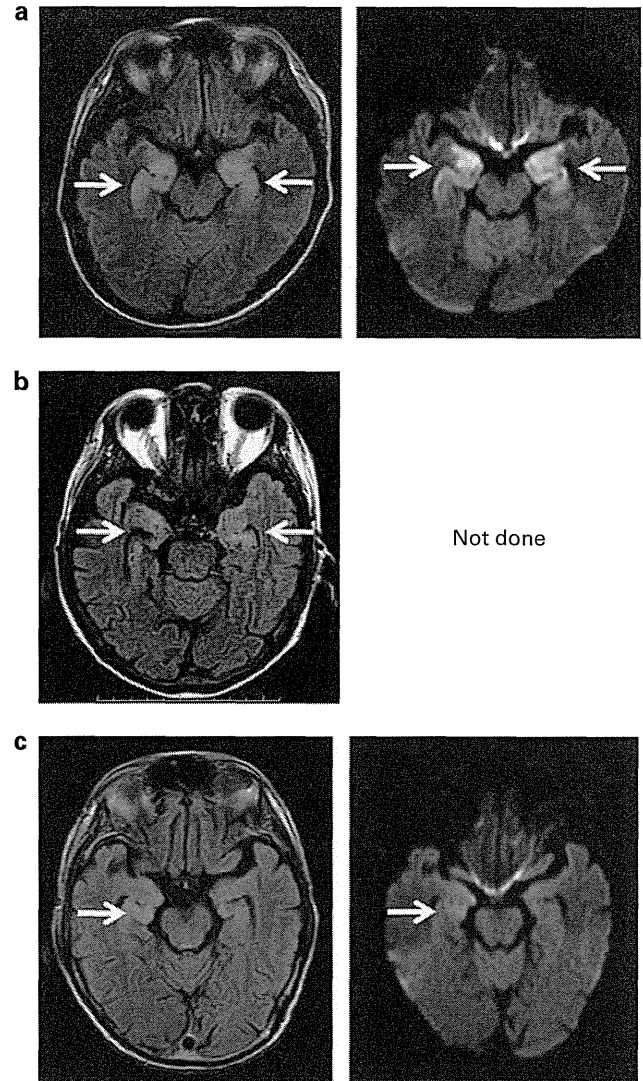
MRI of the brain for the three patients who developed HHV-6 encephalitis in Cohort 2, showing axial images at the level of the basal ganglia. Left side of figure shows T2-weighted fluid-attenuated inversion recovery imaging and right side shows diffusion-weighted imaging. Arrows indicate signal hyperintensities in limbic system. (a) For Patient 1 at 26 days after transplantation, 3 days after onset of neurological symptoms; (b) for Patient 2 at 28 days after SCT, on the day of onset of neurological symptoms; and (c) for Patient 3 at 43 days after SCT, 6 days after onset of neurological symptoms.
